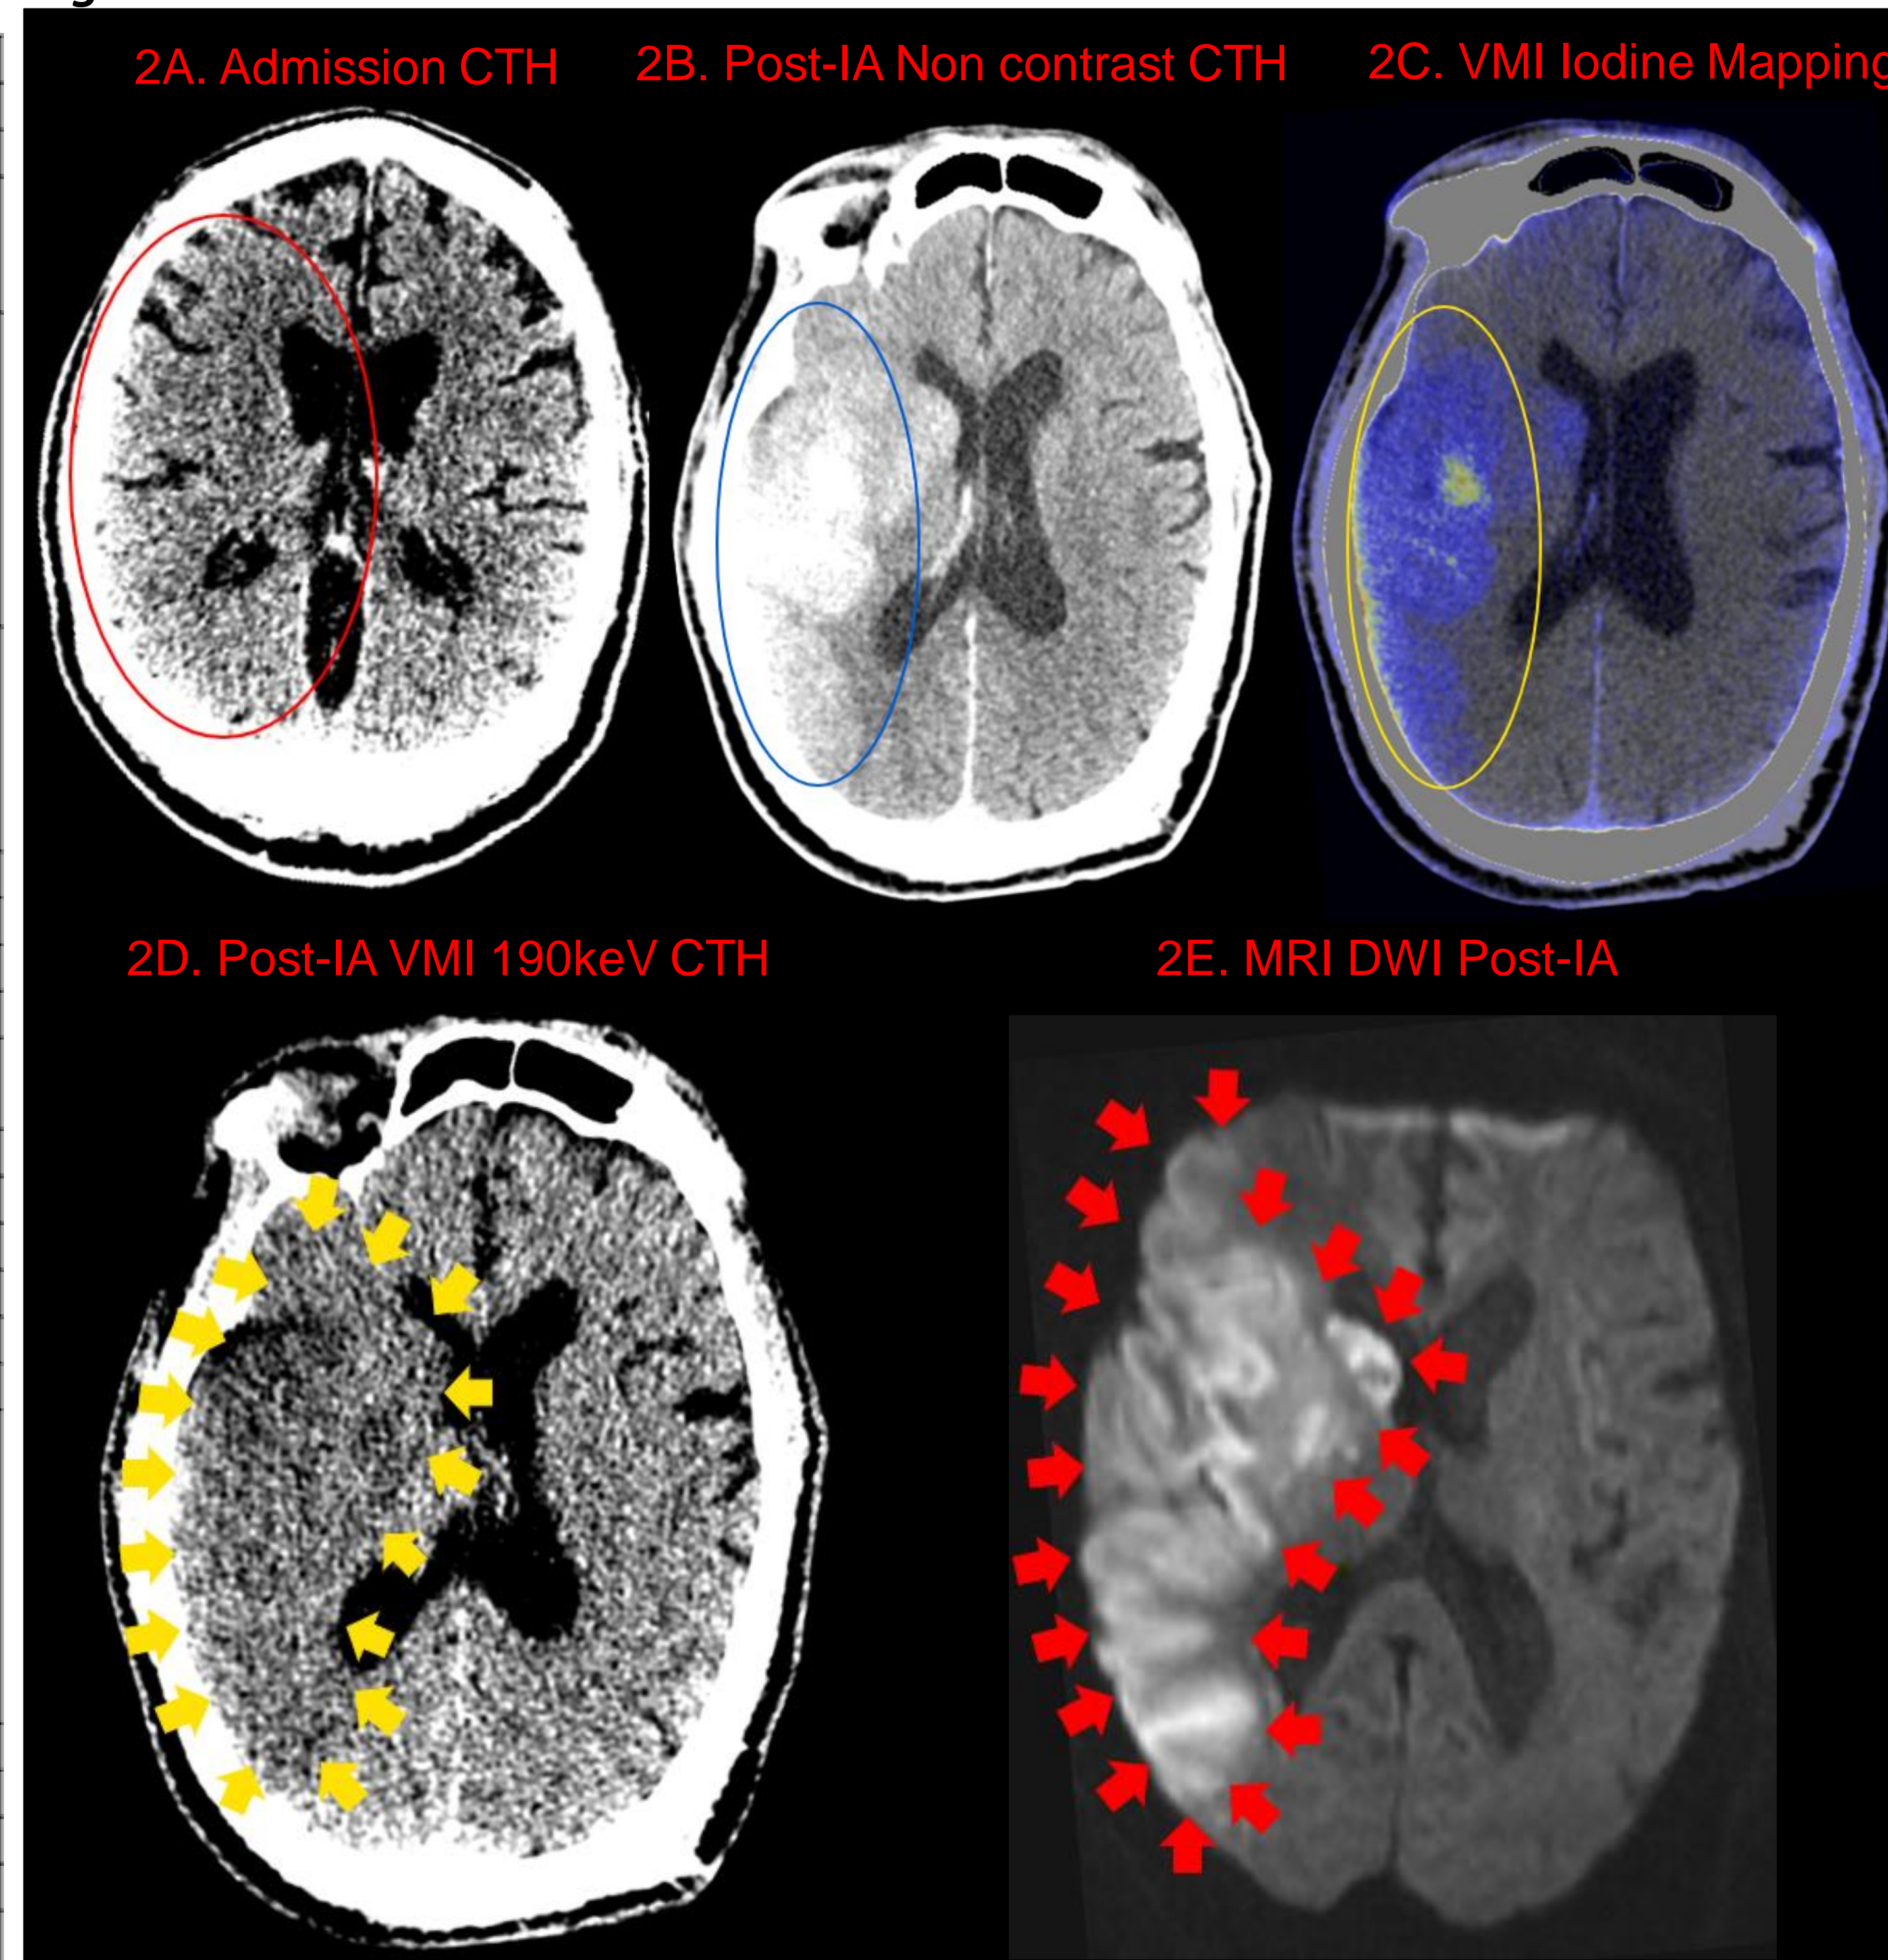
Index patient: 66-year-old male with initial NIHSS 19 found to have R MCA occlusion, obtained TICI 2c reperfusion, with 24hr NIHSS 19. Reperfusion obtained 6hrs. after last known well. Figure 2A: Admission non-contrast CTH (Window length (WL) 30:30) ASPECTS 10. Figure 2B: Post-IA reperfusion, non-contrast CTH (WL 70:30) ASPECTS 4. Figure 2C: VMI brain hemorrhage sequence demonstrating iodine mapping. Figure 2D: VMI monoenergetic 190 keV CTH (WL 30:30) ASPECTS 2 demonstrating early infarct burden, sequence obtained 6 hours post reperfusion. Figure 2E: MRI DWI sequence demonstrating infarct distribution correlating with VMI 190 keV sequence early ischemic changes.
